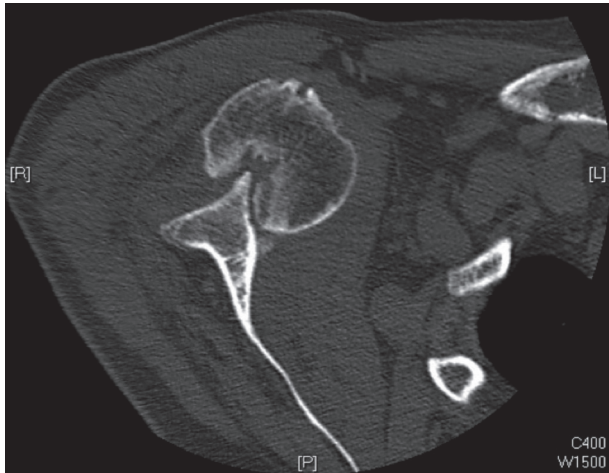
Axial CT image of chronic dislocation with no glenoid bone defect.
